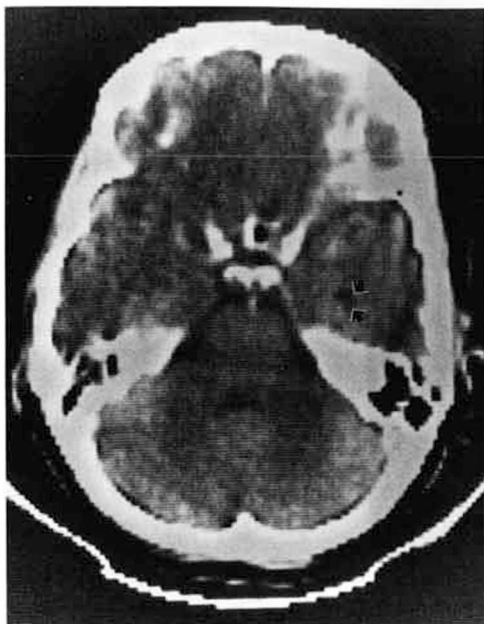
CT scan of patient 1. Small infarct in the medial part of the right temporal lobe (arrow).
